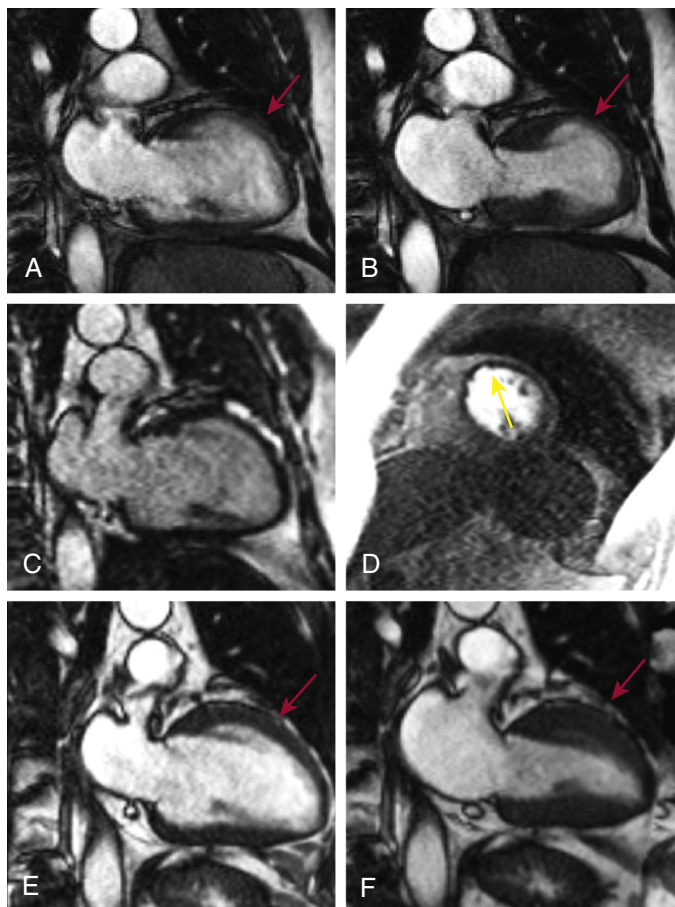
e20 Diastolic (A) and systolic (B) two-chamber cine images demonstrate extensive resting anterior wall thinning, with dyskinesia in systole (*red arrows*). The anterior wall measures <5 mm. (C) Delayed-enhancement cardiac magnetic resonance shows no hyperenhancement, indicating viability of the anterior wall. (D) Resting perfusion scan shows an area of reduced contrast uptake (*yellow arrow*), indicating diminished perfusion of the anterior wall at rest. (E) Diastolic and (F) systolic two-chamber cine images 3 months after revascularization demonstrate improved diastolic wall thickness (8.5 mm) and marked improvement in systolic wall thickening (*arrows*), as predicted from the delayed-enhancement cardiac magnetic resonance imaging.
